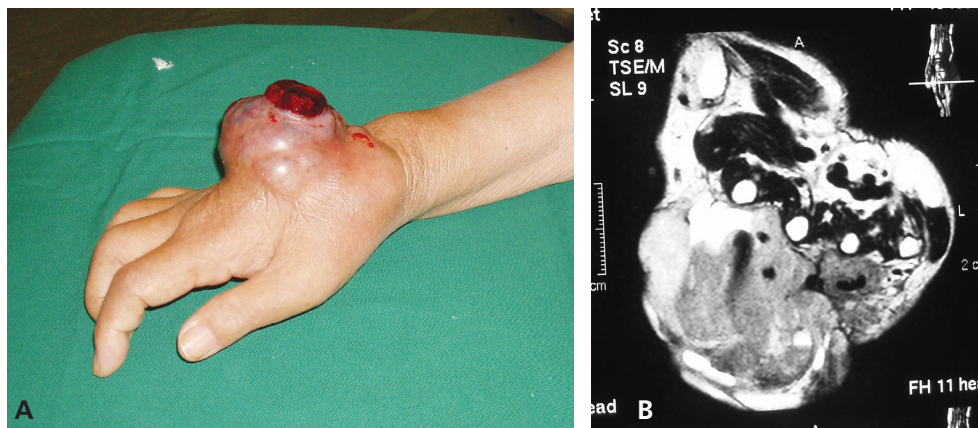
72-year-old female with a recurrent swelling over the dorsum of the hand after two previous excisions. 2A: Photograph of the recurrent swelling. 2B: MRI of the swelling.
